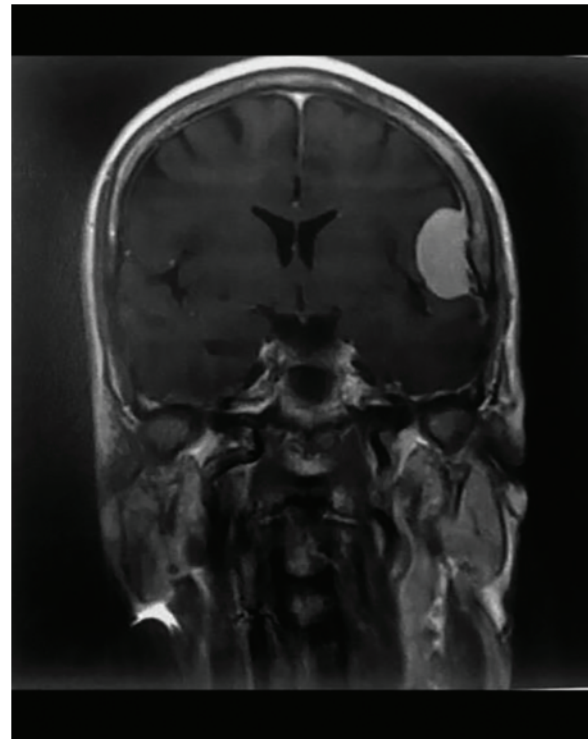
Brain MRI coronal section in T1-weighted after injection of PDC showing a hyperintense extra-axial mass with homogeneous contrast capture.
